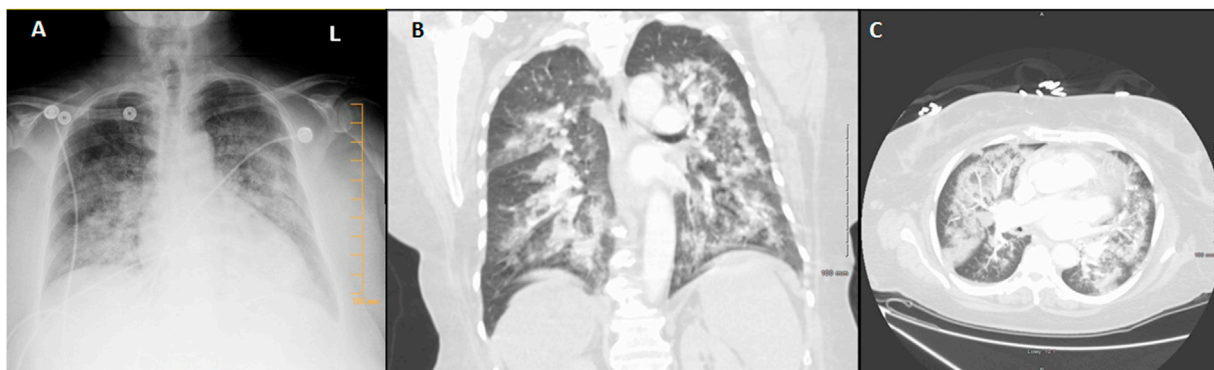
Anteroposterior chest x-ray view (A) showing diffuse interstitial airspace opacities throughout the upper and lower lobes bilaterally. CT chest, coronal plane (B), and transversal plane (C), indicating extensive airspace opacities diffusely involving all lobes.
